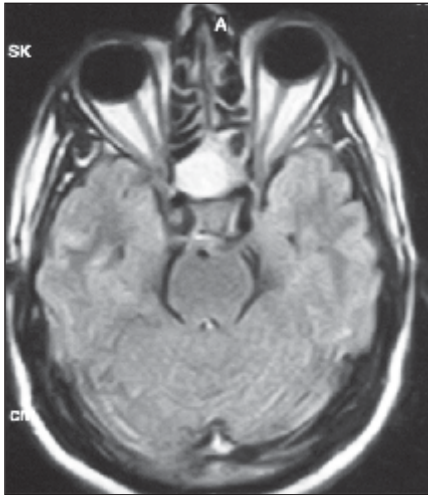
MRI Axial cut T2 weighted image showing Fungus in sphenoid sinus
